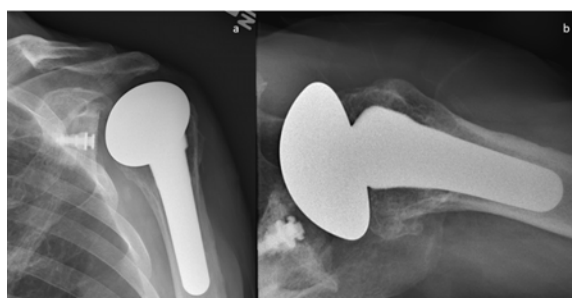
Anteroposterior (a) and axillary (b) radiographs of left shoulder showing anterior subluxation of the humeral head due to subscapularis dysfunction after total shoulder arthroplasty.
